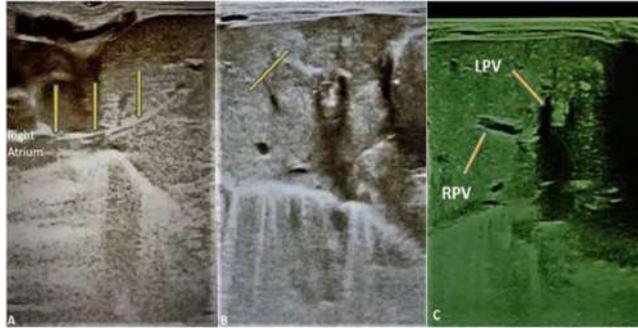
On ultrasound examination, an umbilical venous catheter (arrows) is seen abnormally terminated in the right atrium (A), and a single echogenic nodular lesion (arrows) is seen in the left lobe of the liver (B). In the ultrasound examination of another patient, the left portal vein is seen filled with echogenic thrombus material (arrow) (C). *RPV: right portal vein, LPV: left portal vein.*
